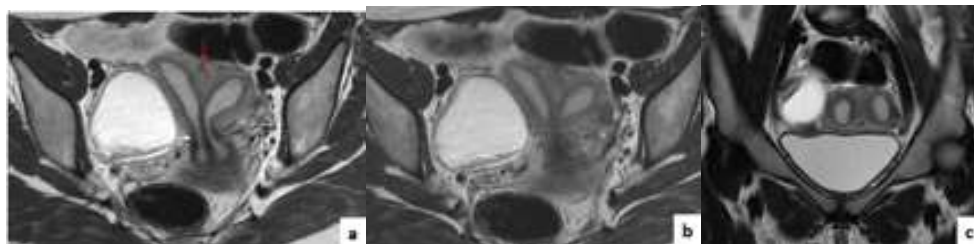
Pelvic MRI in axial T2 (a,b) and coronal T2 (c) views: showing a uterine septum extended to the cervix (white arrow) surrounded by a common serosa (red arrow) in favor of a septate uterus. Radiology Department, Mother and Child Hospital, Hassan II University Hospital, Fez
